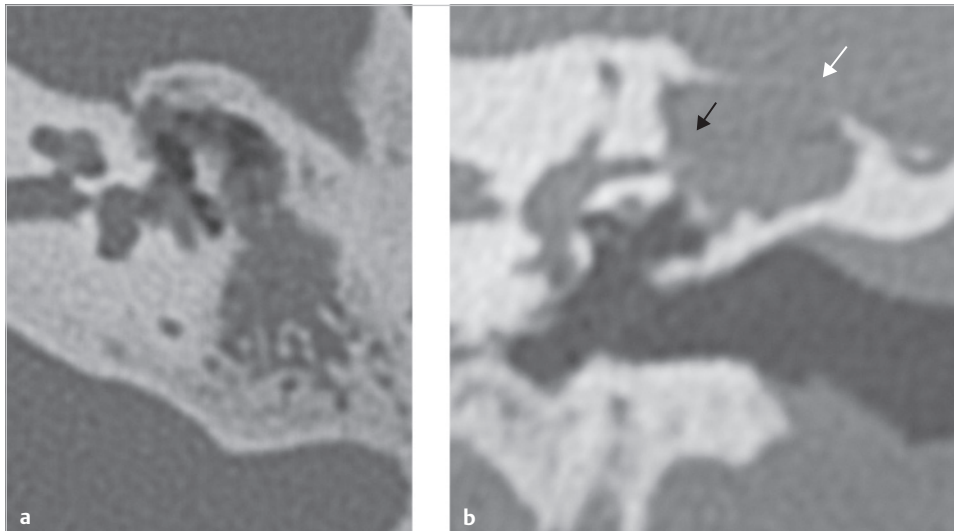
A case of cholesteatoma with suspicion of labyrinthine fistula and exposure of the middle fossa dura. (a) The axial CT shows heavy erosion of the ossicular chain. (b) The coronal CT indicates possibilities of exposed middle fossa dura (*white arrow*), and a fistula in the lateral semicircular canal (*black arrow*).
